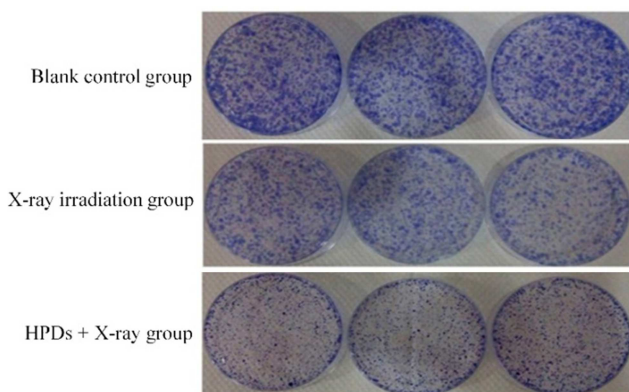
Effects of X-ray irradiation alone and HPDs + X-ray irradiation on A549 cell clone formation.
